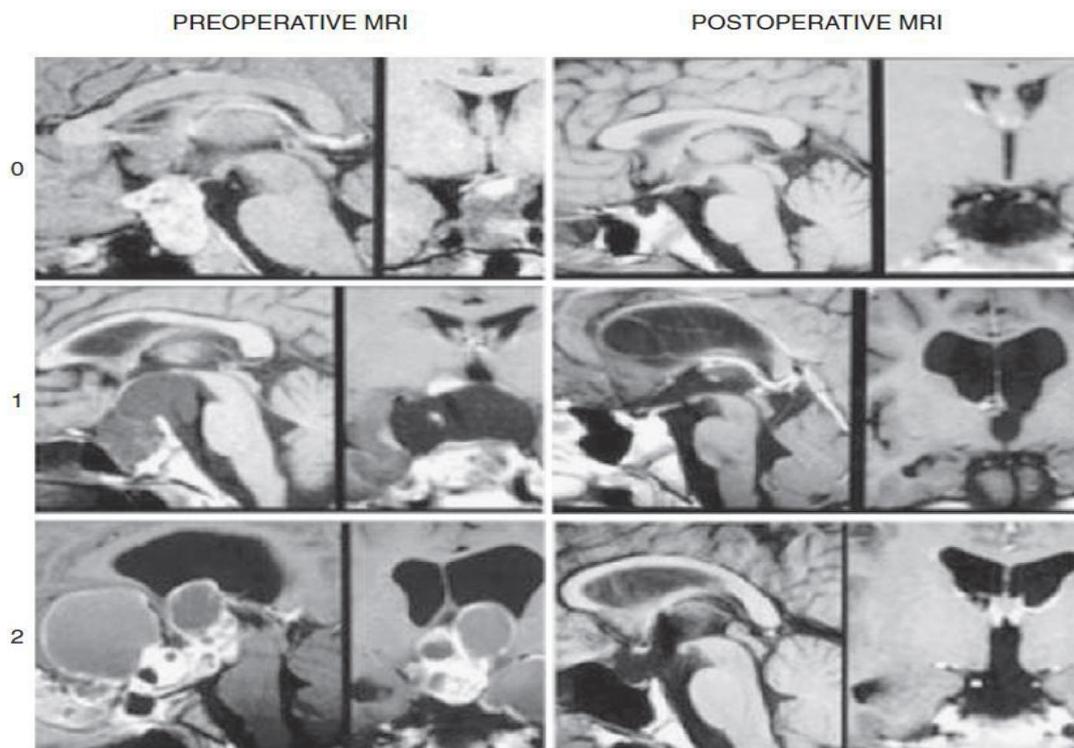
MRI Classification of Craniopharyngiomas in Children.
